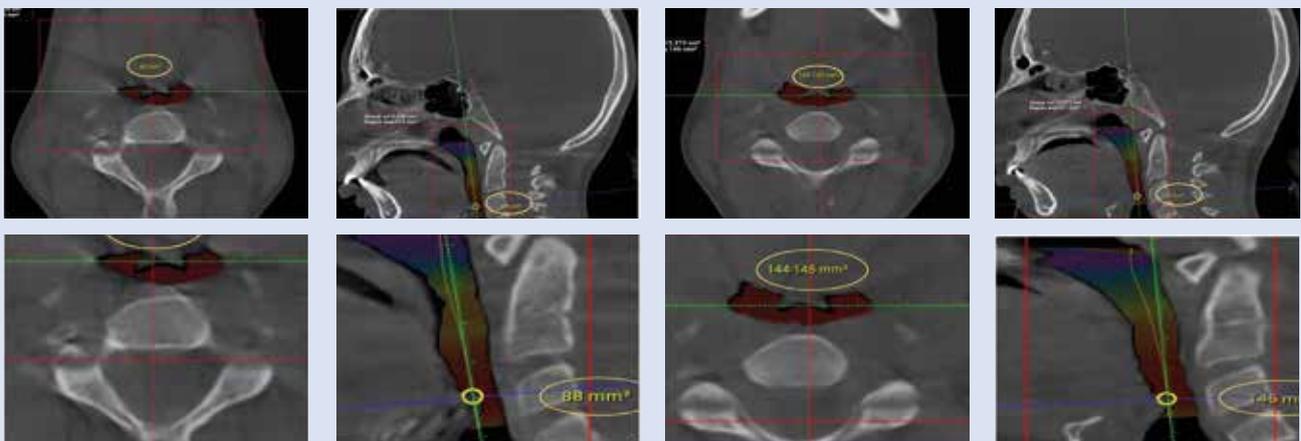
Comparison of radiographic examinations, showing the narrowest part of airway increased from 88 mm² to 145 mm² (65% increase in area), that resulted in a significant reduction in upper airway resistance.
